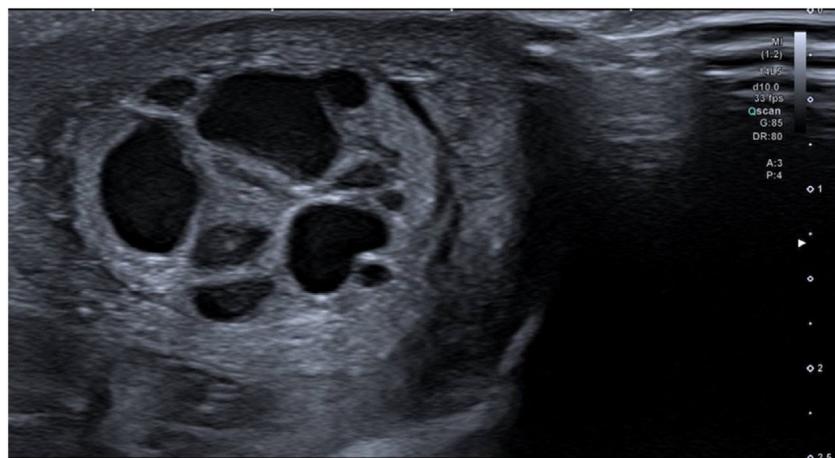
Testicular ultrasound scan: multicystic septate lesion.
